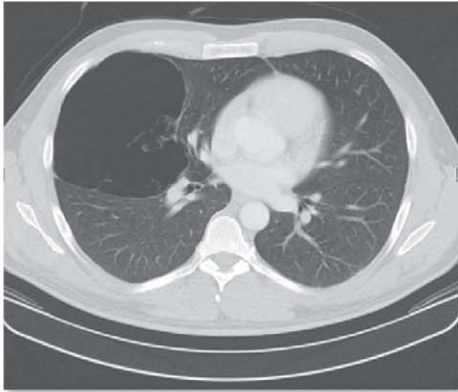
CT of the chest showing a large bulla of 16 cm diameter in the right hemithorax
